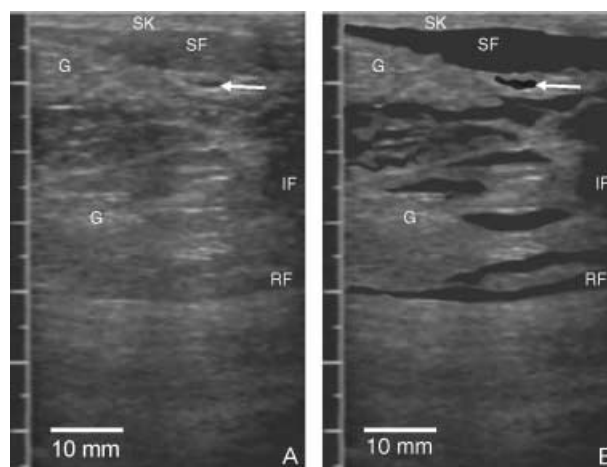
(A) Ultrasound image of tissues of the lactating breast. (B) The skin (SK) is shown as an echogenic (bright) line at the top of the image. The subcutaneous fat (SF) is less echogenic and situated below the skin. The intraglandular fat (IF) is of similar echogenicity to the subcutaneous fat. The glandular tissue is echogenic (G) while the milk duct (arrow) appears as a hypoechoic (low echo) tubular structure. The retromammary fat (RF) is a thin hypoechoic band along the chest wall.
